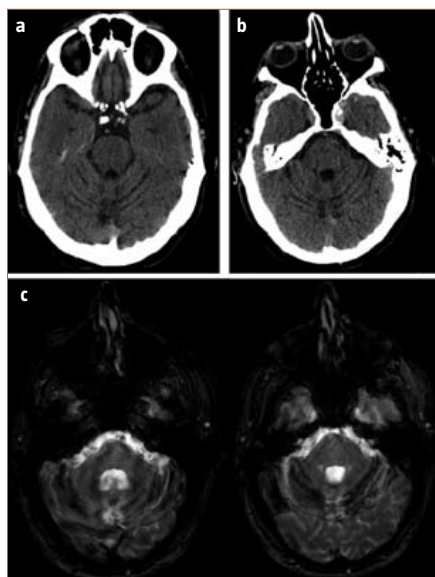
Head computerized tomography in 2010 (a) and 2014 (b), and brain magnetic resonance imaging in 2014, T₂* weighted images (c).
